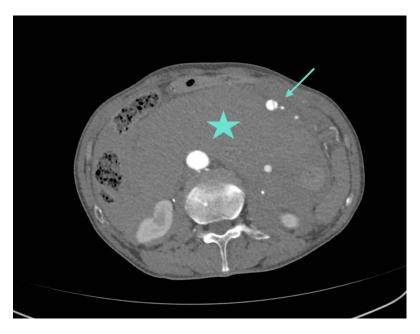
Abdominal contrast-enhanced computed tomography scan. The asterisk indicates a retroperitoneal hematoma, and the arrow denotes a mesenteric artery dissection.
